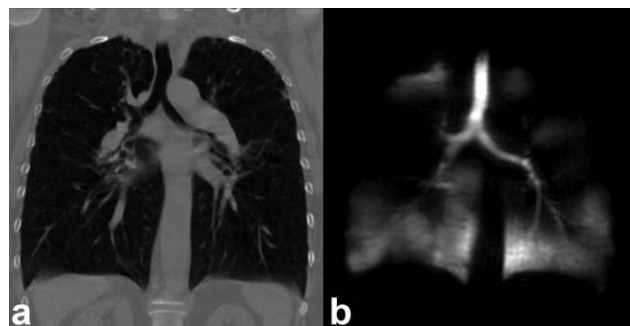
Comparison of HRCT and HP He MRI in COPD. Female COPD subject, 63-year-old with FEV₁ predicted = 22%. a: Center slice coronal plane reconstruction of HRCT. b: HP He MRI center coronal slice ventilation image.
